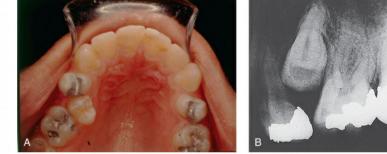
(A) Occlusal view of the permanent dentition following bilateral premature extractions of the maxillary primary second molars. The right second bicuspid erupted ectopically, and the left is impacted. (B) Radiograph of the area showing the impacted left
